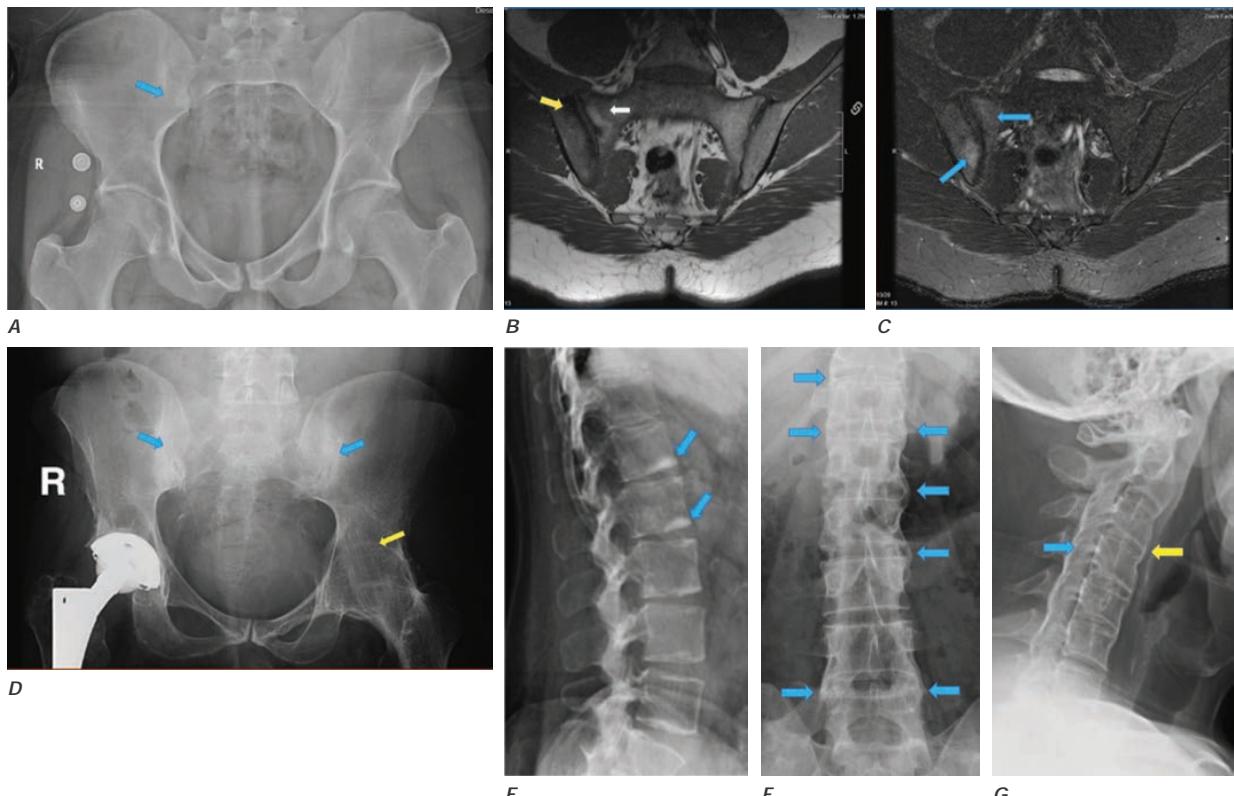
Imaging in nonradiographic axial spondyloarthritis (nr-axSpA) and in ankylosing spondylitis (radiographic axial spondyloarthritis).
